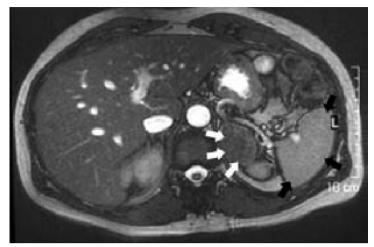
MRI features of adrenal malignancy. This left adrenal neoplasm is big, irregularly oblong, and dark in this MRI "out of phase" acquisition. It presents a finely irregular structure, with a "salt and pepper" aspect (*arrows*) due to necrotic phenomena. All these aspects suggest a malignant adrenal mass
